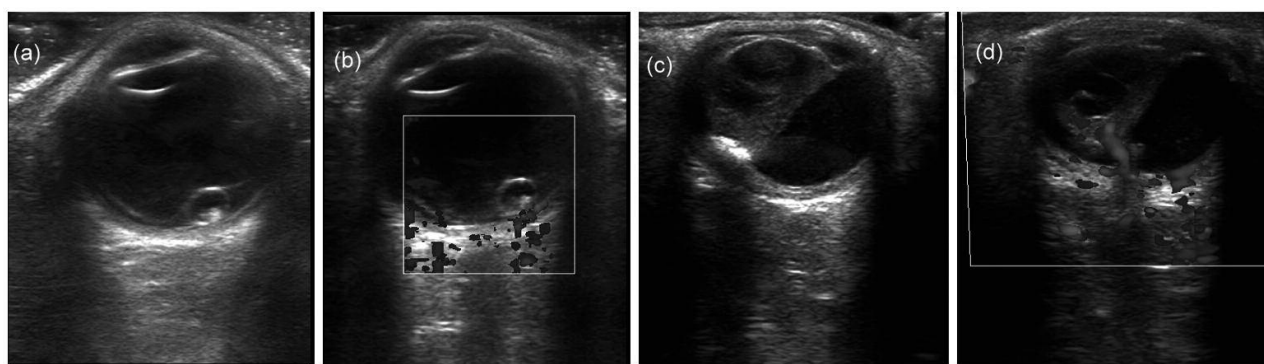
(a): Ultrasound (B scan) of left eye showing a well-defined hypoechoic oval structure with a hyperechoic focus within, at intra-retinal location. This represent cysticercus cyst with scolex within. There is separation of retinal layers with fluid accumulation in between the layers of retina.
